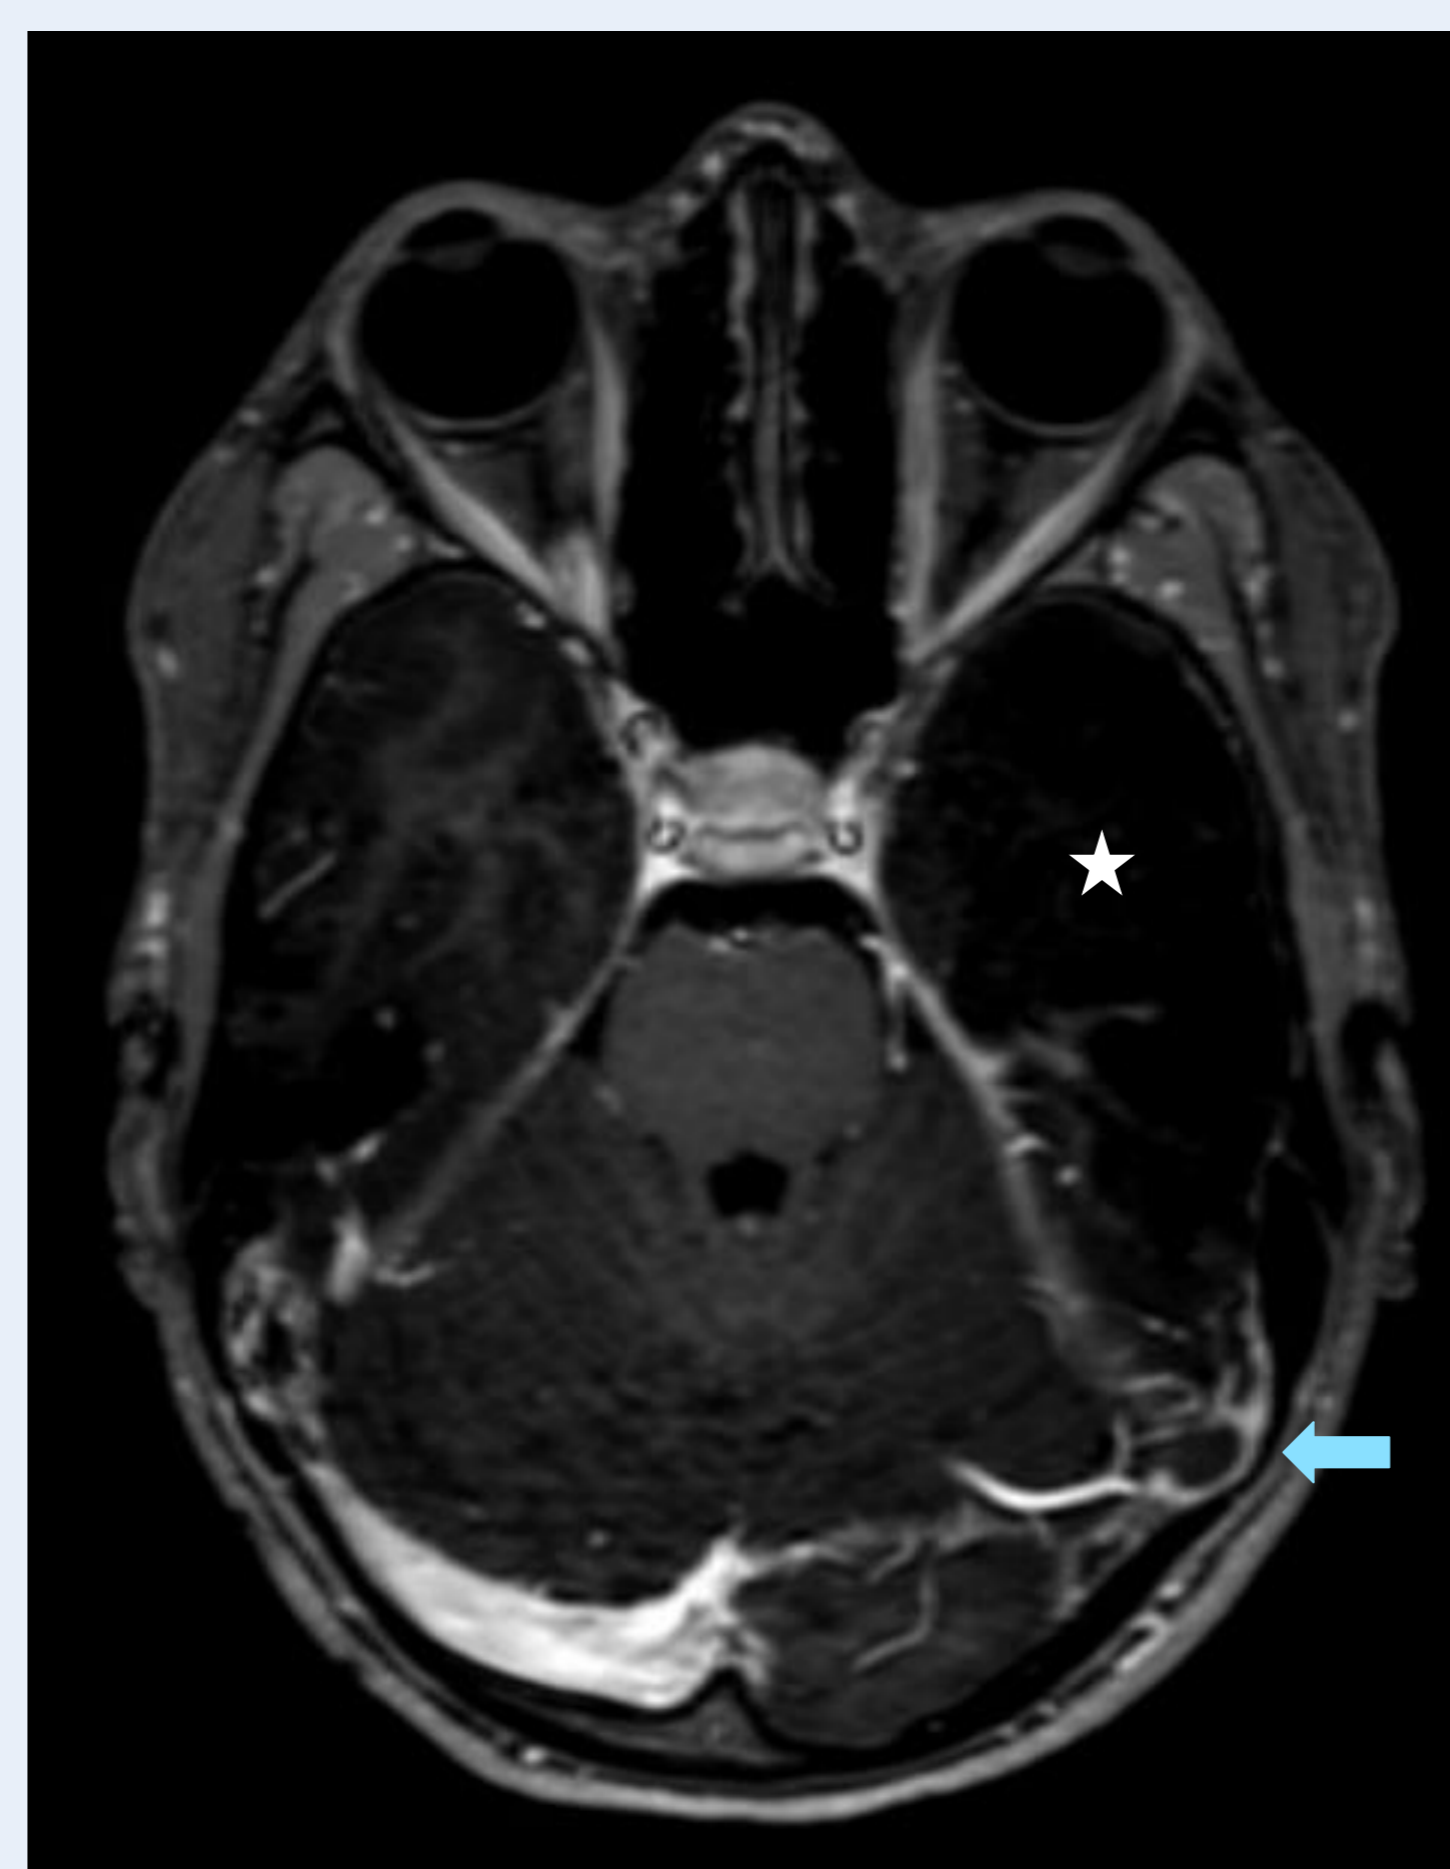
postoperative MRI scan demonstrating the left anterior temporal lobectomy (white asterisk) and the presence of a thrombus in the junction of the left sinus transversus and sinus sigmoideus (blue arrows).
